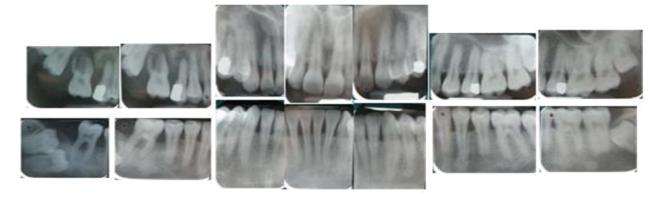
Full mouth periapical that revealed severe bone loss in right sextants without any bone loss in other regions
